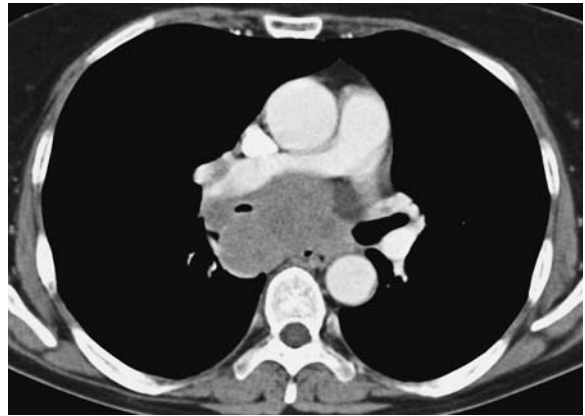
Transverse CT section of a double-lung transplant recipient shows a large subcarinal mass suggestive of post transplant lymphoproliferative disease
